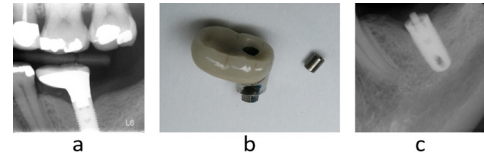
Abutment screw fracture: a. radiographic view before complication; b. restoration separated from implant with fractured screw head; c. shank and threaded end of screw still inside the implant.
